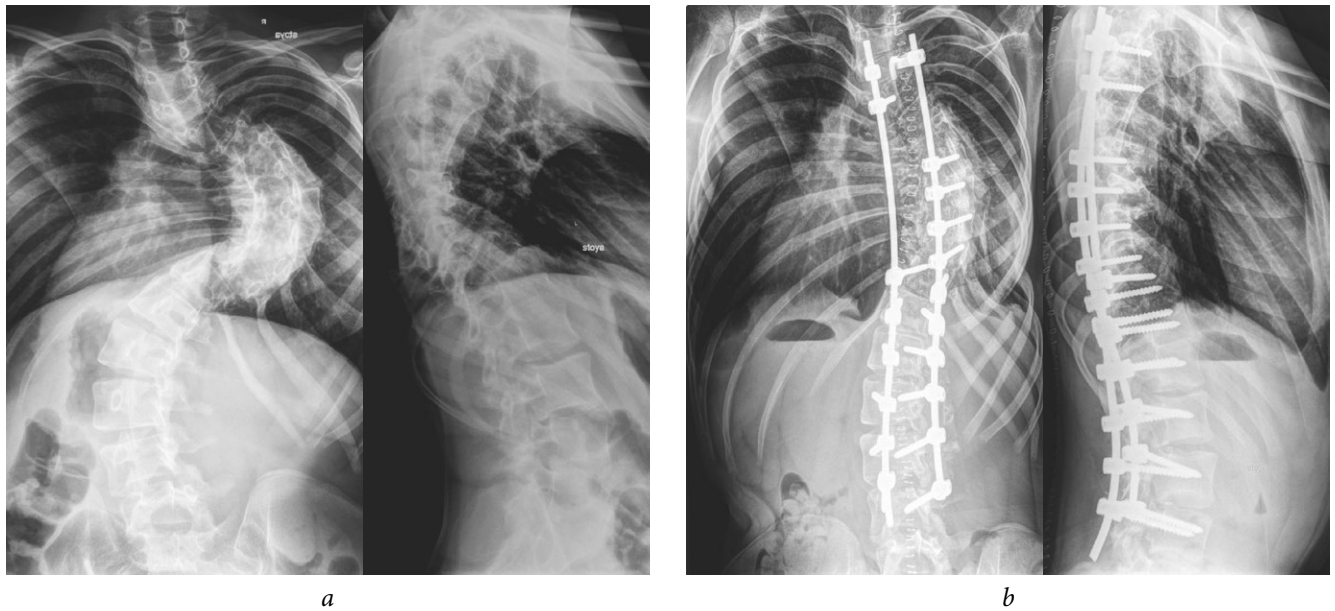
Radiographs of patient S., aged 17: *a* — before the surgery; *b* — after discectomy, fusion, halotibial traction course, and correction of the deformity by a multisupport surgical hardware system in combination with wedge resection of the vertebral body Th₇
